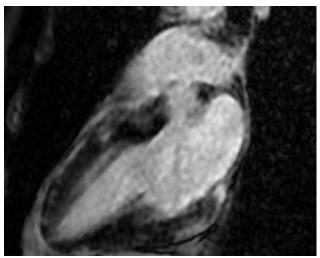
Cardiac MRILeft ventricular short axis, 4 and two chamber imaging in gadolinium enhanced T1-weighted sequence showing a late gadolinium enhancement located in the subepicardial area of anterior, lateral and posterior walls (mid and basal segments).
